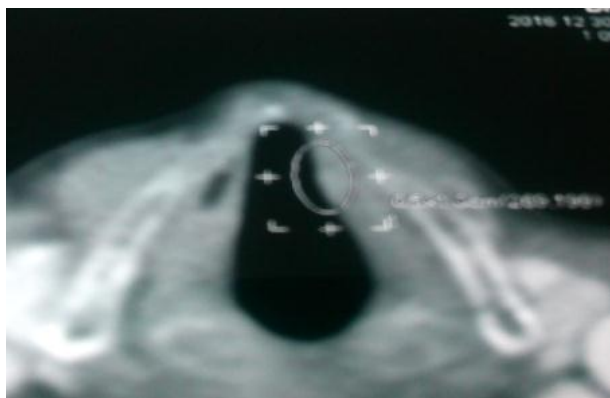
Computed tomography neck showing minimal thickening of size 5×1 cm involving the left true vocal cord.
